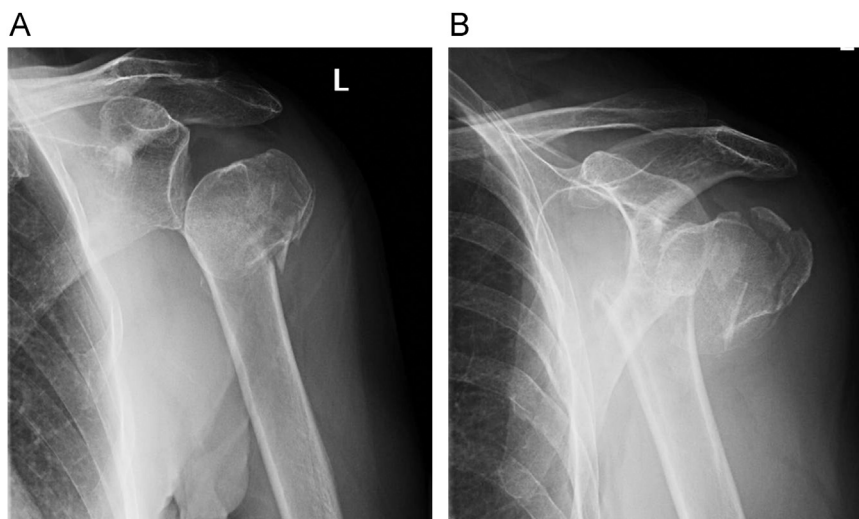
(A) True AP and (B) AP radiographs demonstrating a three-part proximal humerus fracture with significant tuberosity comminution, which is an example of the type of fracture that is amenable for reverse total shoulder arthroplasty.
